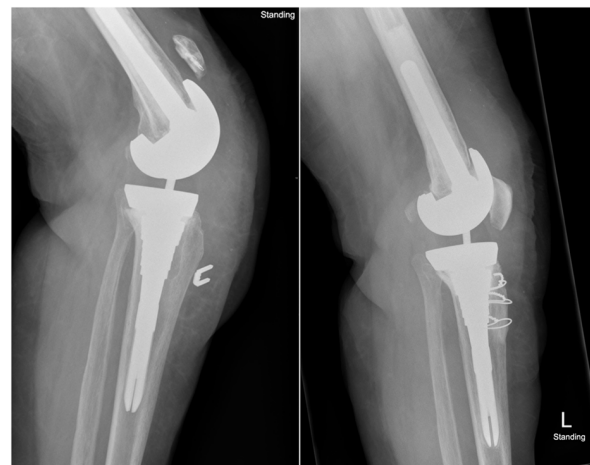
Radiograph showing pre and postoperative reconstruction using extensor mechanism (EM) allograft.
